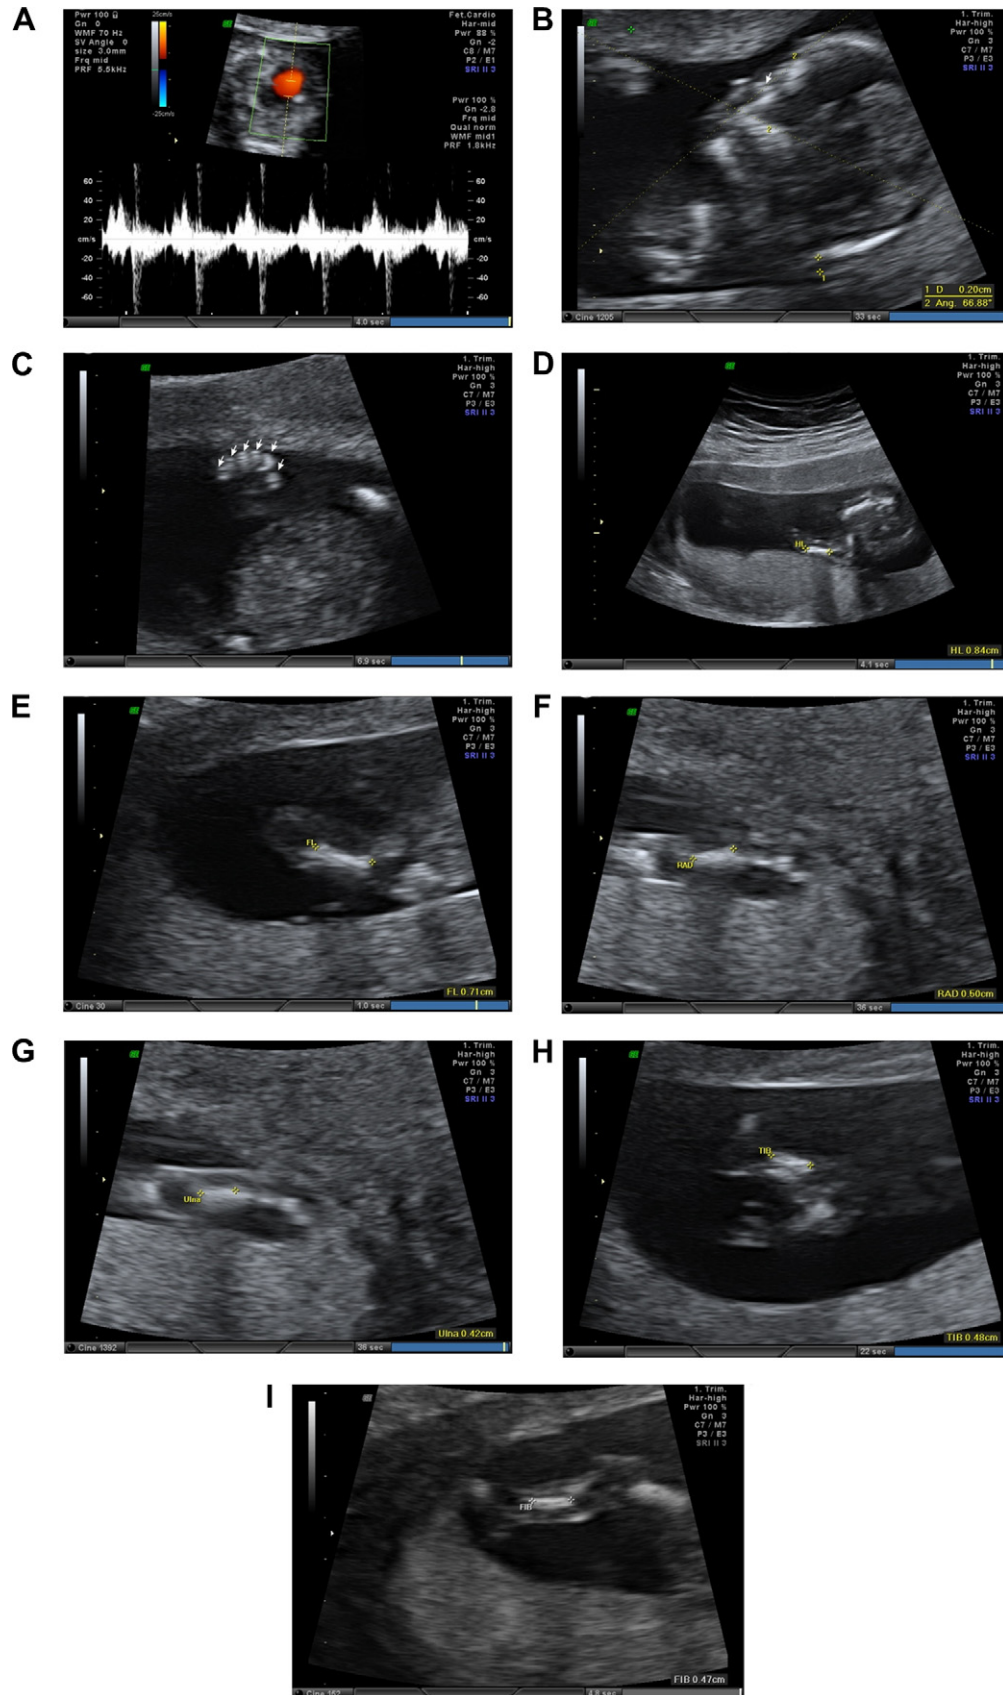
Prenatal transabdominal ultrasound at 13⁺4 weeks of gestation shows (A) an endocardial cushion defect, (B) a nuchal translucency thickness of 2.0 mm, (C) postaxial polydactyly of the hand, and mesomelic dysplasia of the long bones of (D) humerus, (E) femur, (F) radius, (G) ulna, (H) tibia, and (I) fibula.
